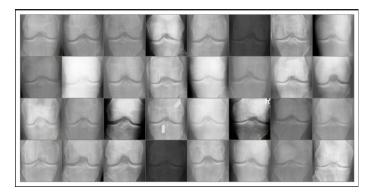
Sample X-ray Images
